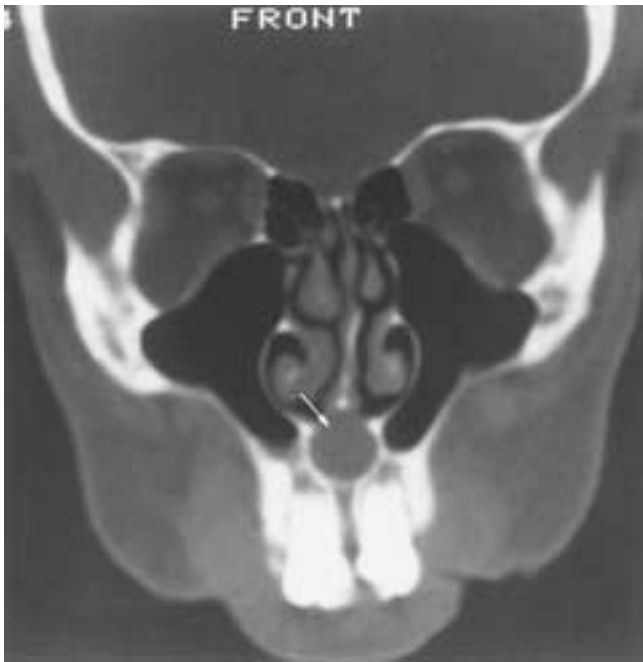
Nasopalatine cyst. Coronal CT (bone window setting) shows a cyst with bony expansion in the nasopalatine duct between the upper central incisor teeth (*arrow*). There is a slight bulge into the adjacent nasal cavity.
